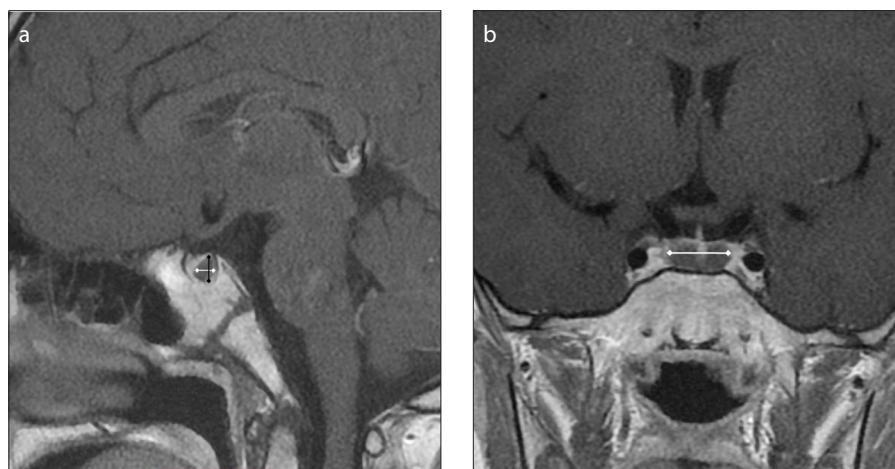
a, b. Sagittal contrast-enhanced T1-weighted image (a) shows the measurements of the maximum height (*black arrow*) and anterior-posterior diameter (*white arrow*) of the Rathke's cleft cyst (RCC). Coronal contrast-enhanced T1-weighted image (b) shows the measurement of the maximum width of the RCC (*white arrow*).
